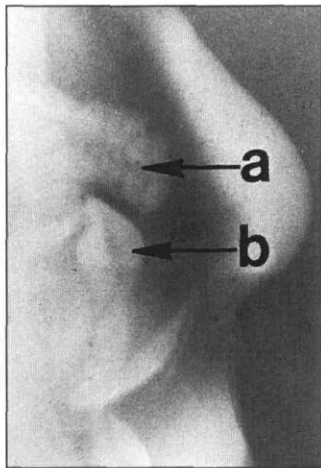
Extraoral lateral radiograph of nasal area of a five-year, 10-month-old white male with unilateral complete cleft of the lip, alveolar process and palate on the right side. Arrow (a) — irregular radiopaque area containing accretions surrounding small pieces of aluminum foil. Arrow (b) — supernumerary tooth in right nasal fossa.
